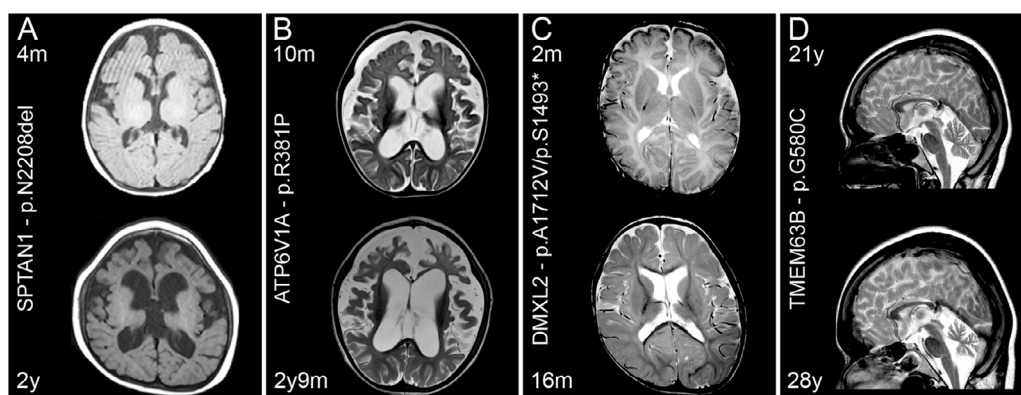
Progression of structural MRI abnormalities in DEE5, DEE93, DEE81, and TMEM63B-related DEE. Sets of brain MRI of patients carrying pathogenic variants in SPTAN1 (A, images taken at 4 months and 2 years), ATP6V1A (B, images taken at 10 months and 2 years 9 months), DMXL2 (C, images taken at 2 months and 16 months), and TMEM63B (D, images taken at 21 years and 28 years). For each patient, the pathogenic variant is indicated on the right side of the panel. Note the progressive dilatation of the ventricles and subarachnoid spaces in A, B, and C and the progressive cerebellar atrophy in D.
